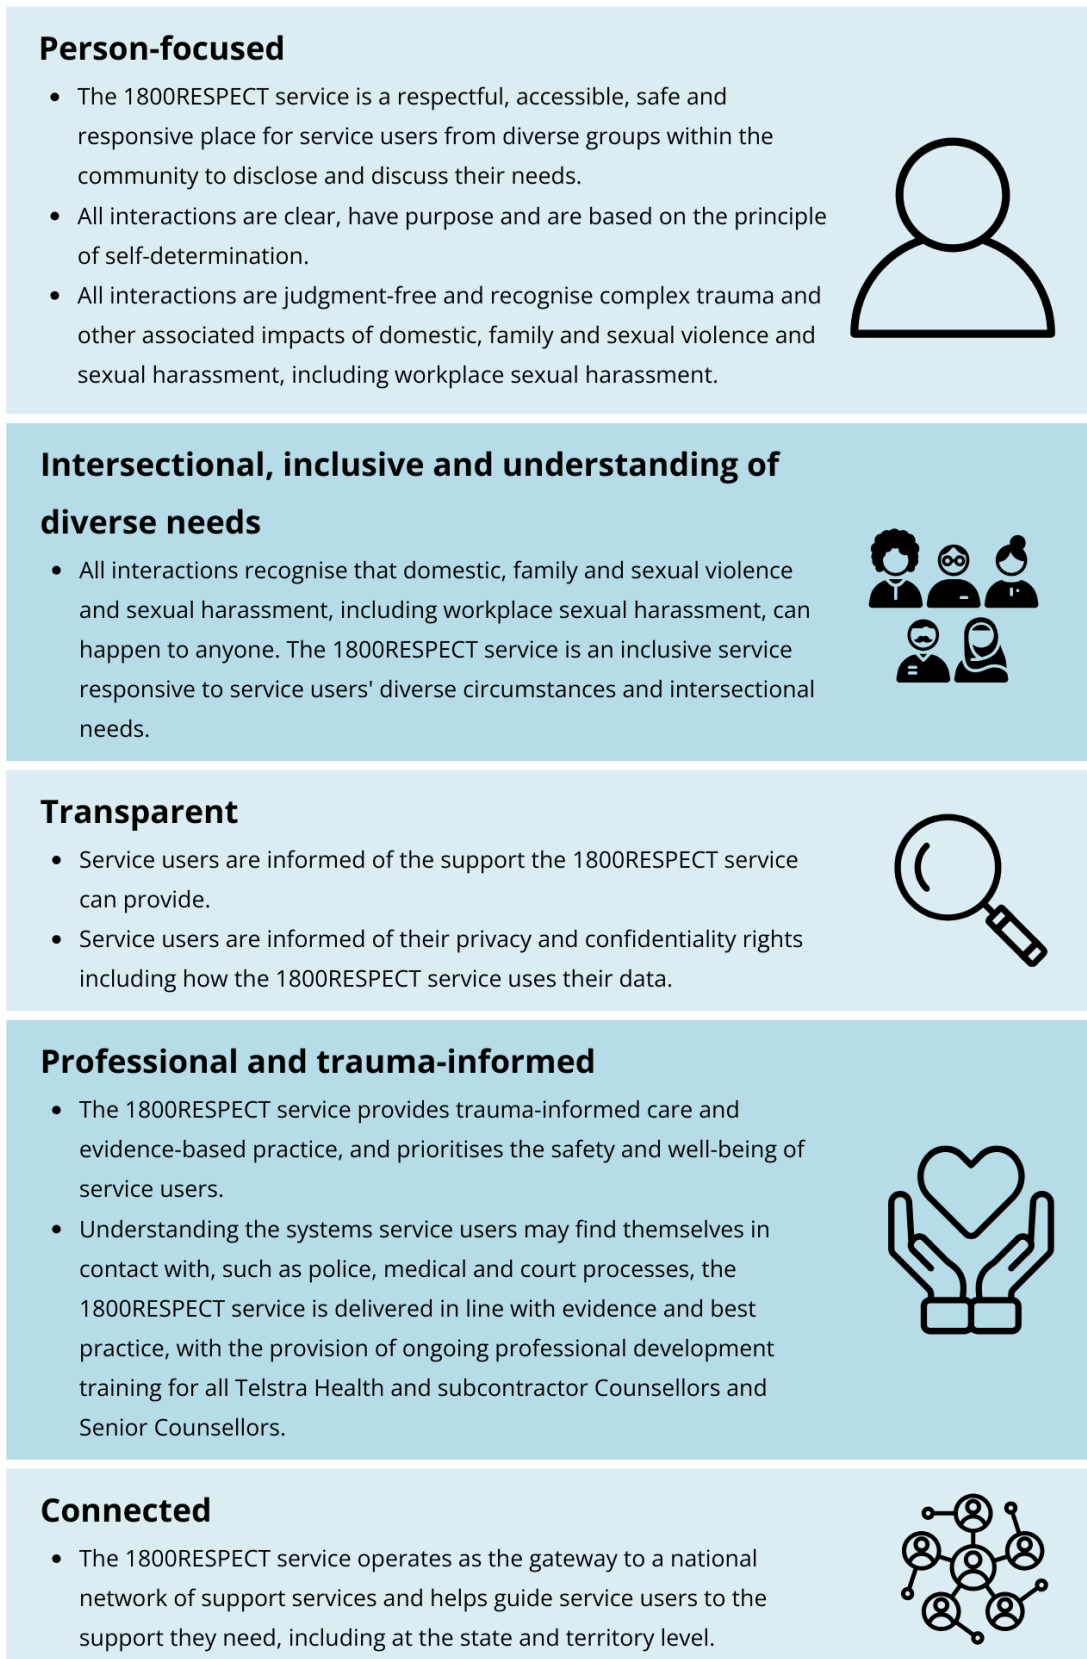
1800RESPECT delivery model
